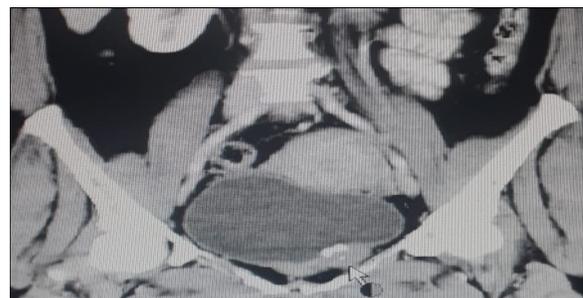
CT appearance of bladder Leiomyoma in case 2
